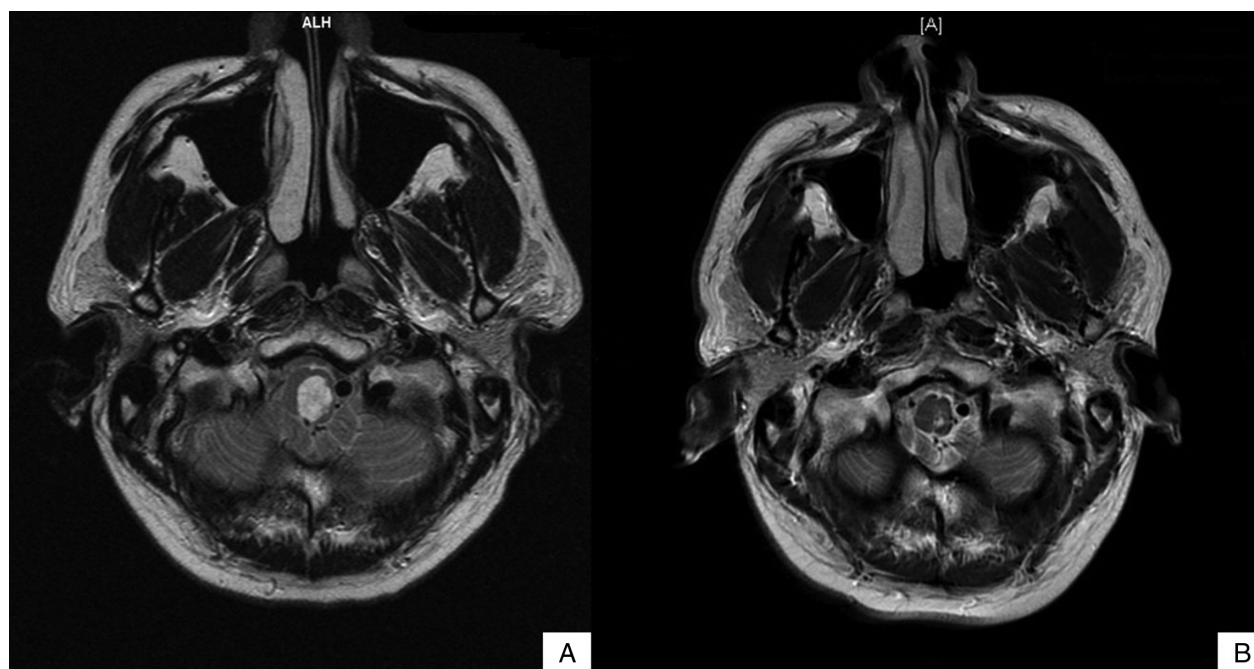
T2-weighted magnetic resonance imaging of the brainstem showing partial response in the medulla oblongata metastasis with alectinib treatment. (a) Medulla oblongata metastasis while on ceritinib for 30 months and after CyberKnife treatment, measuring 10 × 13 × 18 mm. (b) Medulla oblongata metastasis after 6 months of alectinib treatment, which showed interval reduction in size and enhancement, measuring 3 × 5 mm.
